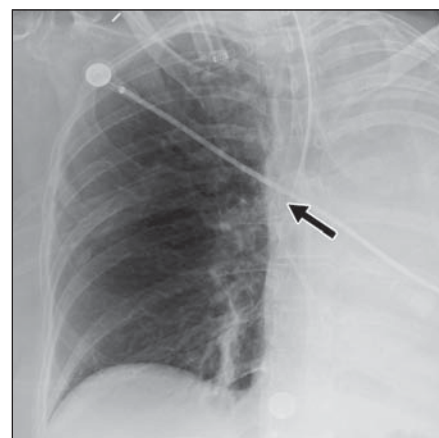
60-year-old woman with inadvertent right main bronchial intubation. Anteroposterior chest radiograph shows endotracheal tube tip (arrow) in right main bronchus, resulting in complete collapse of left lung and leftward shift of mediastinum. →
